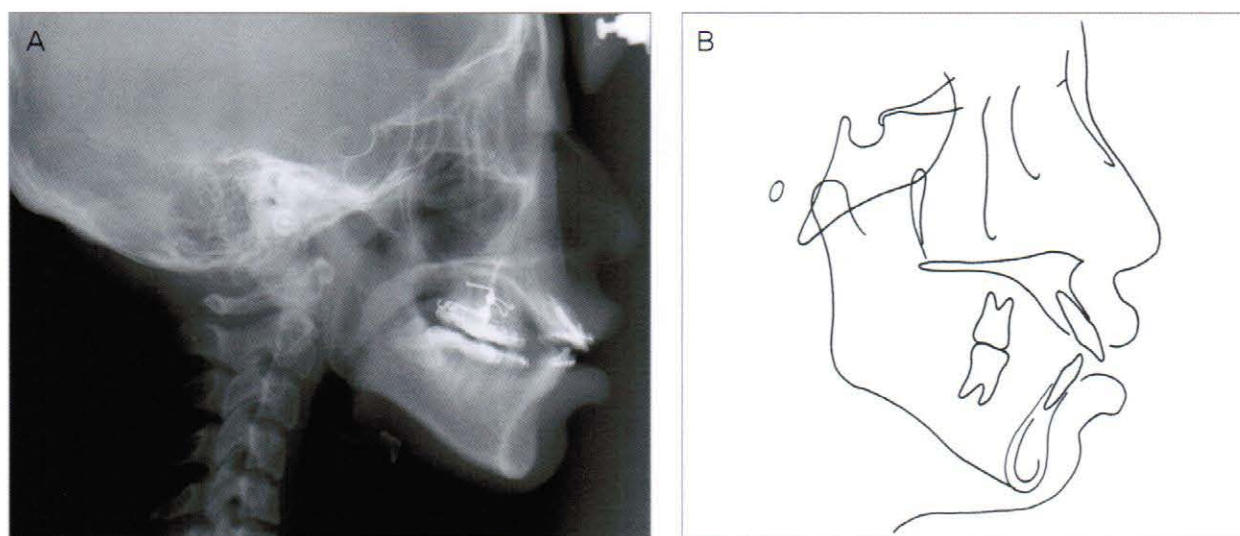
Cephalometric radiograph (A) and tracing before intrusion of the upper right second molar (2004, 3,24)
